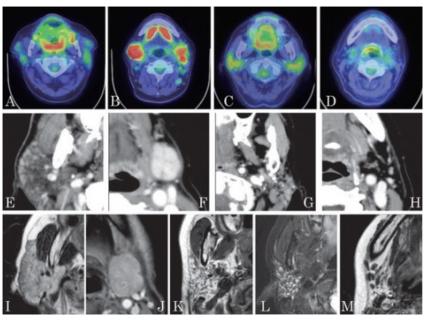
IgG-4 RD. FDG-PET/CT (A-D), CT (E-H) and T2-weighted MRI (I-M). Sialedenitis of the parotid and submandibular glands in IgG4-RD and SD.
